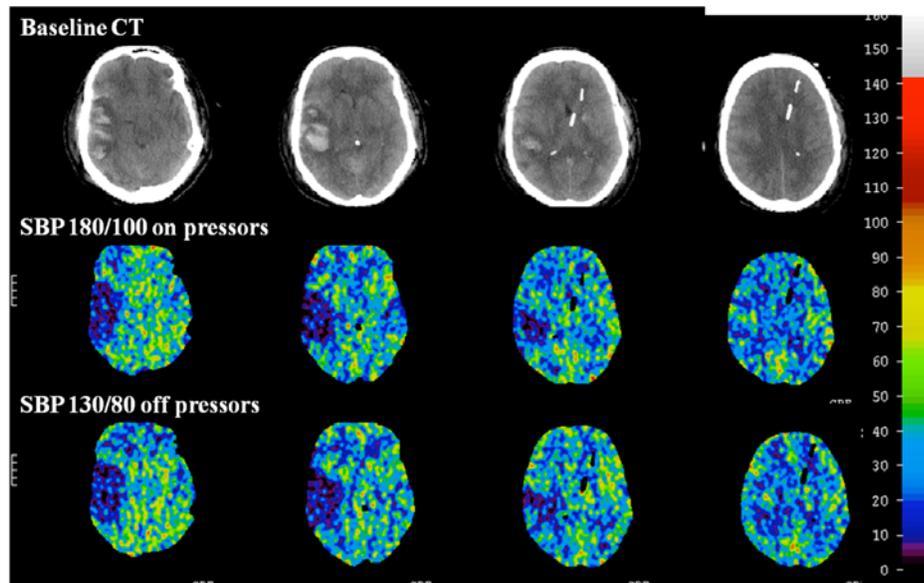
Four level xenon/CT CBF study from case 3. Note that despite manipulation of blood pressure with pressors, CBF remains essentially unchanged.
